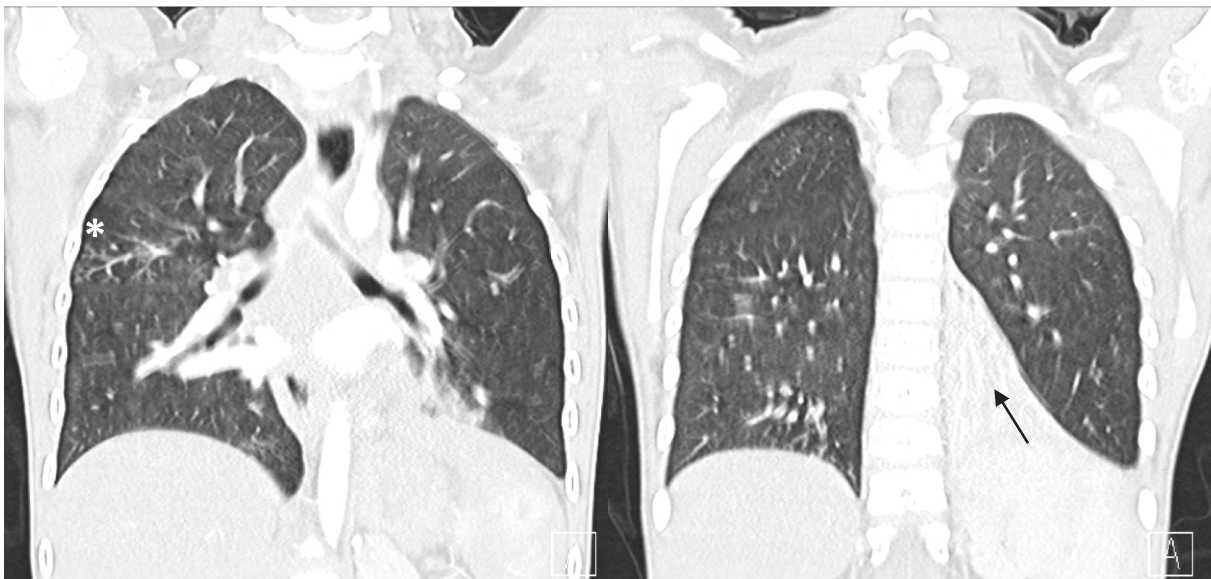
Thorax computed tomography coronal images at the age of 6 years showing tree-in-bud sign (white star), atelectasis (black arrow) and bronchiectasis with mucoid impactions.
